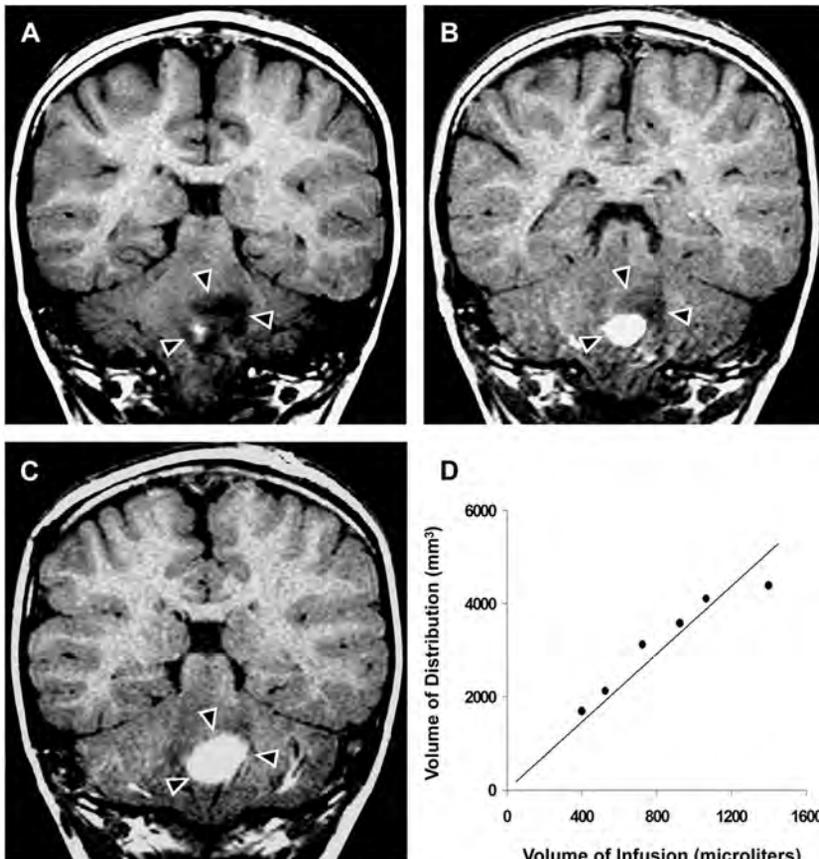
Real-time MR imaging of convective distribution of interleukin-13 bound to *Pseudomonas* toxin (IL13-PE) and gadolinium-DTPA in a diffuse brainstem glioma. A–C, Serial coronal T1-weighted MR imaging during convection-enhanced delivery of IL13-PE co-infused with a surrogate MR imaging tracer, gadolinium-DTPA (total volume infused, 1.4 mL). Sequential imaging during infusion demonstrates perfusion of the hypointense tumor (arrowheads) in the pons with drug as shown by the region filled with gadolinium-DTPA (white area). D, Volume of distribution increases linearly with volume of infusion ($R^2 = 0.92$). The overall volume of distribution to volume of infusion ratio was 3.7 ± 0.4 .
